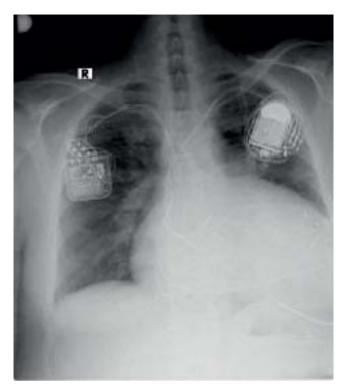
Chest X-ray in a patient supported with CRT-D (left side of the thorax) and CCM device (right side of the thorax).
